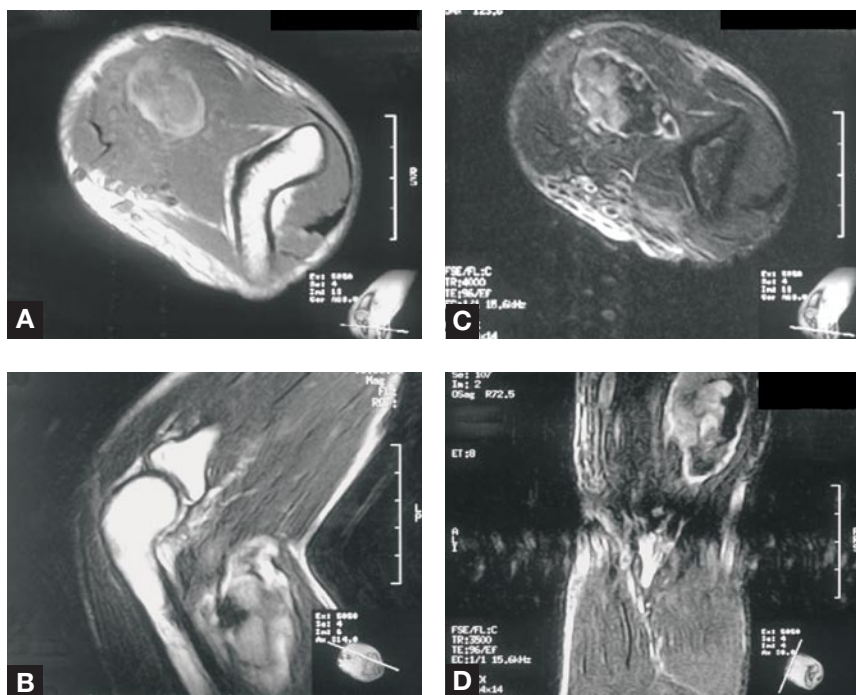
Case 2—Magnetic resonance imaging shows a heterogenous soft-tissue mass with areas of mixed signal in both T₁- and T₂-weighted images. The hematoma measured 5.0x2.5x2.7 cm in greatest dimensions. (A) axial T₁-weighted image, (B) coronal T₁-weighted image, (C) axial fat-suppression T₂-weighted image, and (D) sagittal fat-suppression T₂-weighted image.
